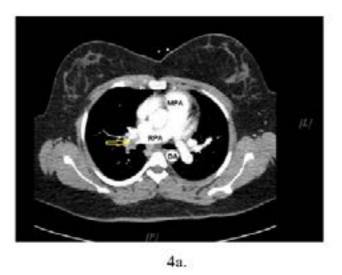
Computed tomography angiogram of the chest, axial images showing extensive bilateral pulmonary emboli including a large embolus at the right pulmonary artery (arrow). A) There is enlargement of the pulmonary arterial trunk. Main pulmonary artery trunk is dilated. Additionally, a patchy irregular ground glass opacities bilaterally is noted; B) evidence of subsegmental extension of the embolus. MPA, main pulmonary artery; RPA, right pulmonary artery; DA, descending aorta.
